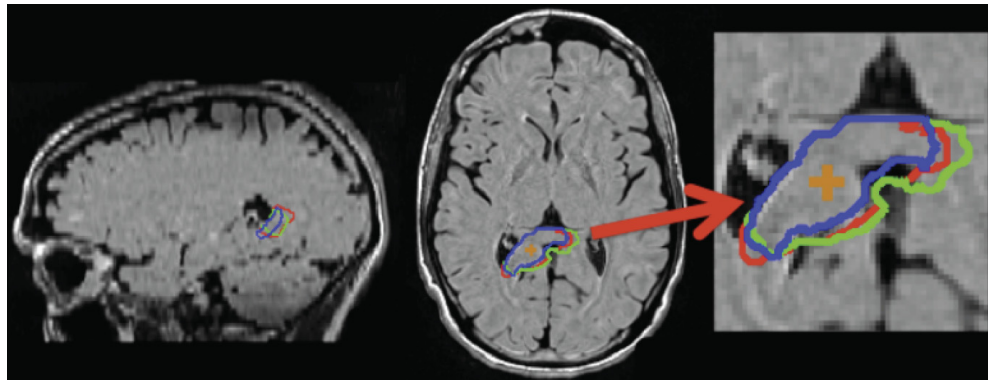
High-resolution synthetically grown tumors overlaid on a registered T1 MRI. Displays the differences in tumor growth patterns when the tumor results are thresholded at similar volumes. Notice that similar tumor shapes between the high and low resolution images.
